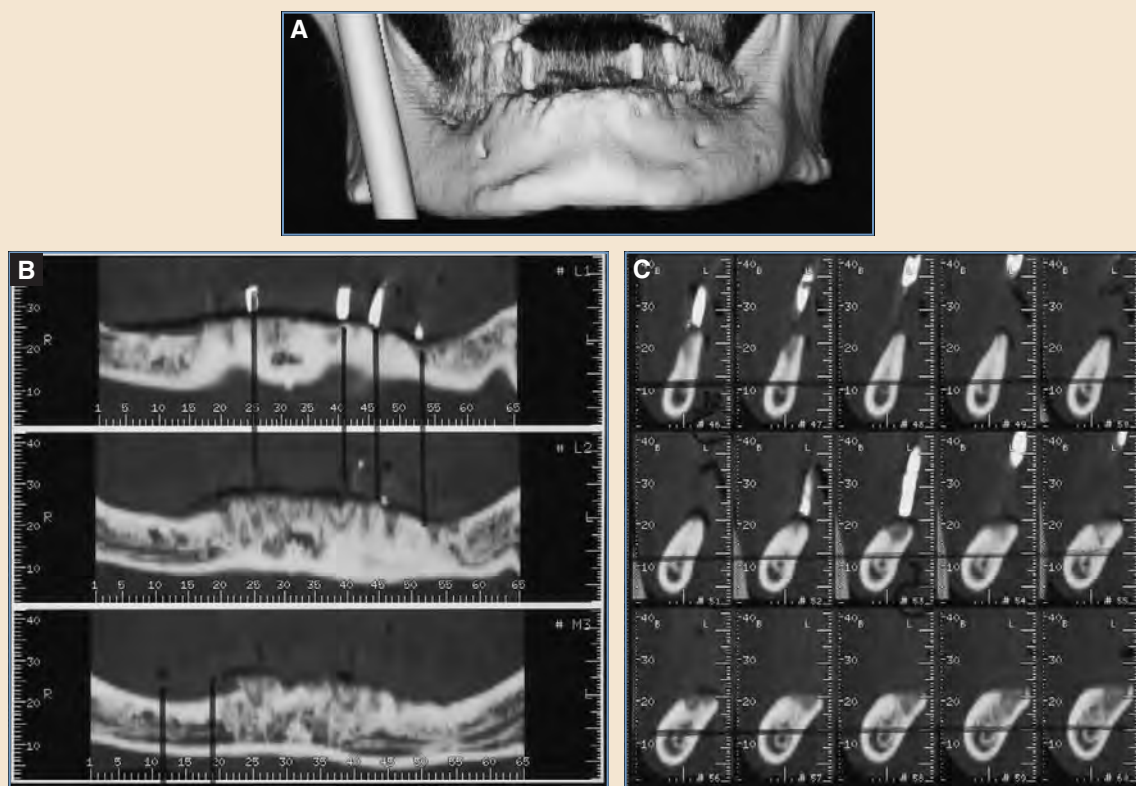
A, The DentaScan is a CT imaging device that allows millimeter measurements of bone in the den-toalveolar region. B, Two-dimensional renderings of the jaws have each representative slice numbered in order. C, Cross-sectional images of the jaws are fabricated and numerically coded to identify the exact location of the image. The quality and quantity of bone in each location can be assessed for placing osteointegrated implants.
